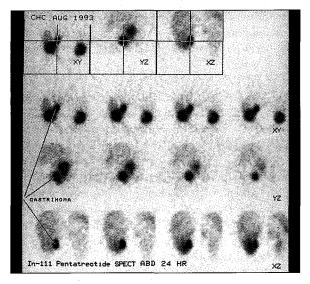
Gastrinoma in the abdomen. SPECT study of the abdomen 24 hours shows focal "hot" spot on the axial [a], sagittal [b] and [c] coronal reconstructions.
